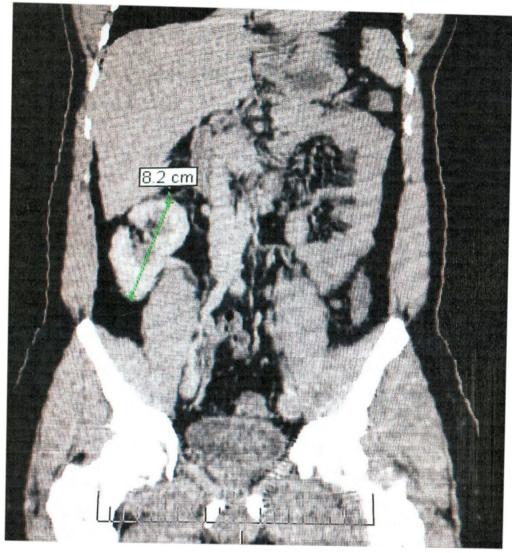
Coronal reformatted computed tomogram showing the right lower kidney which measured 8.2 cm in bipolar length
